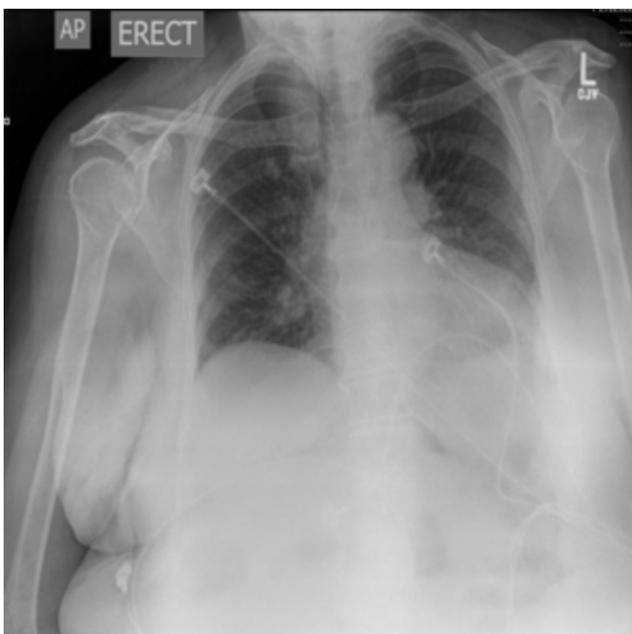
Chest X-ray showing no infiltrates or consolidation at the time of admission.
